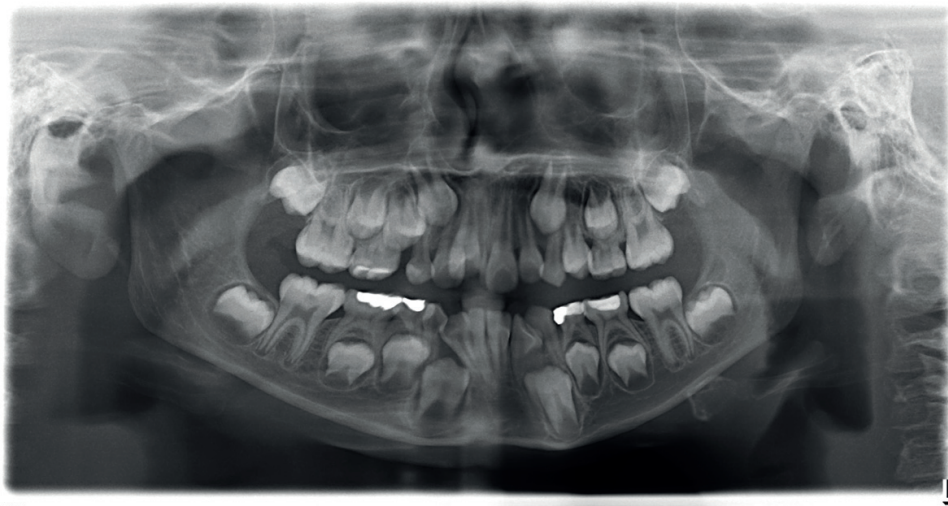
Panographic radiograph.
